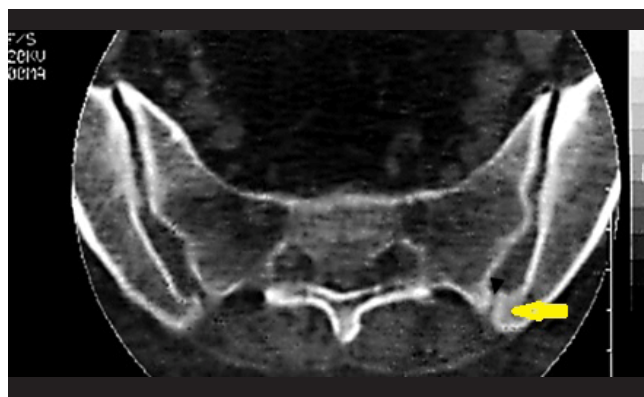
On the CT image, the yellow arrow shows the left side accessory sacroiliac joint.
